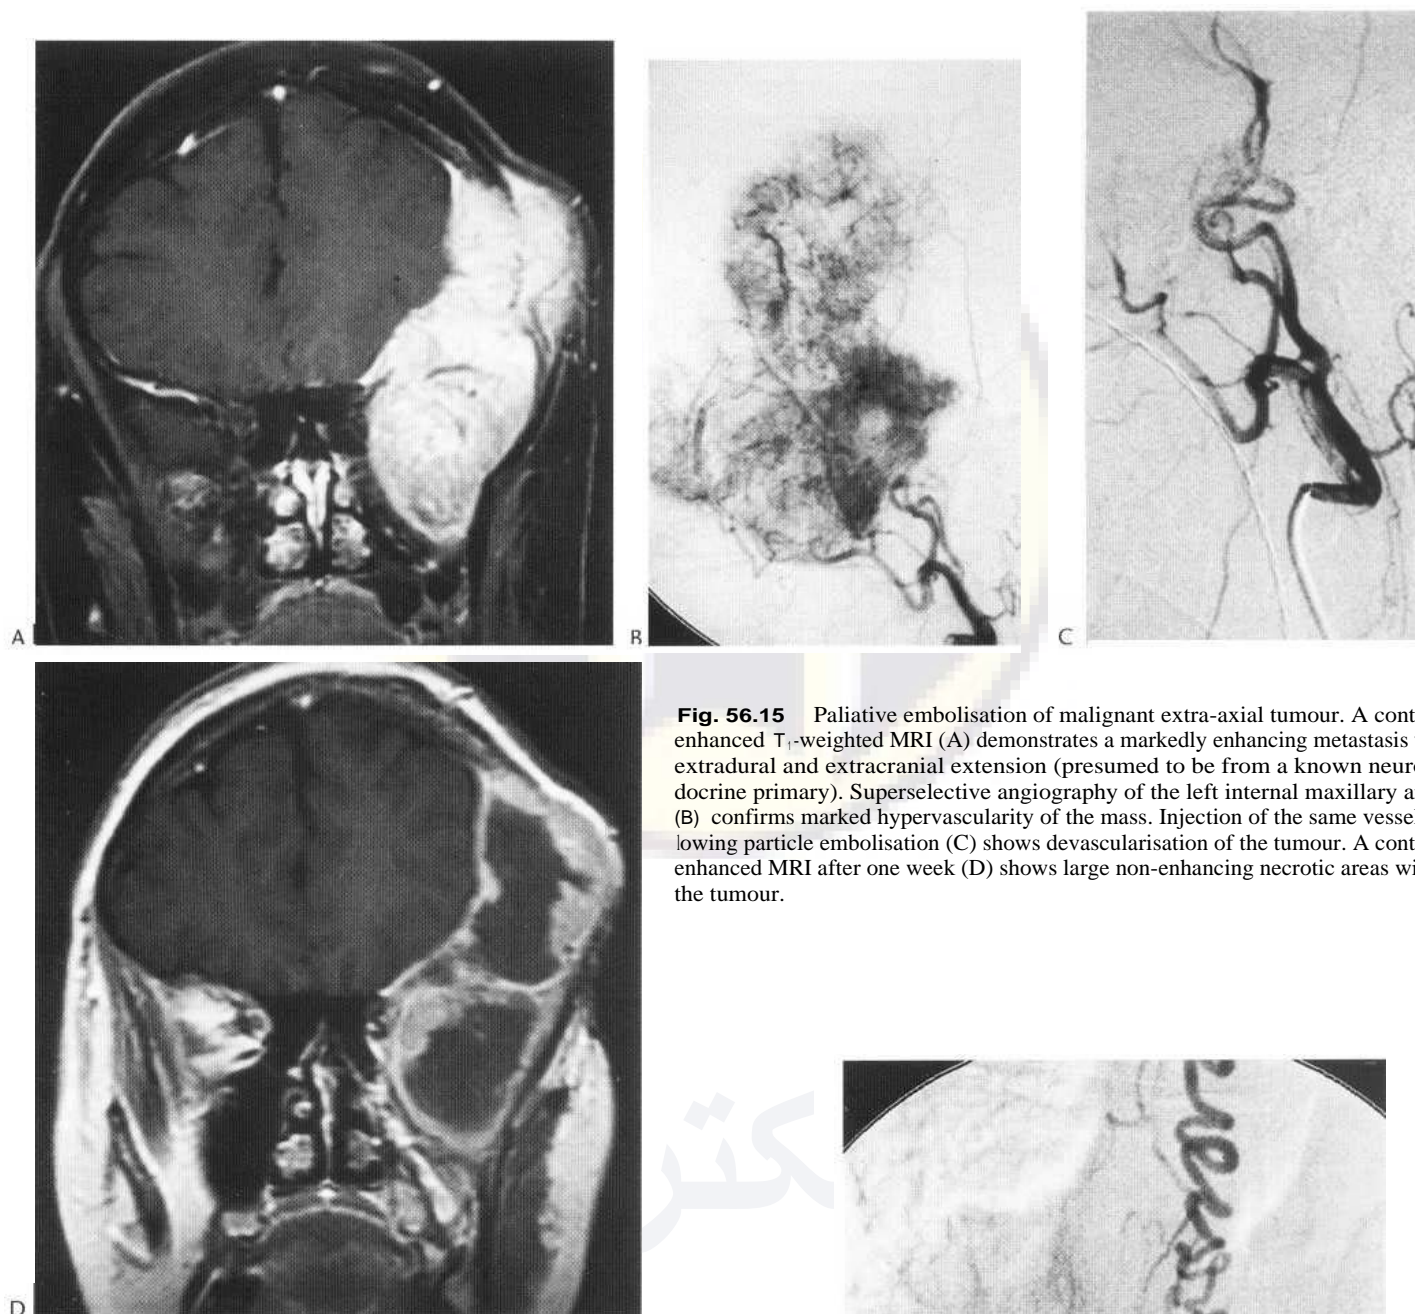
Paliative embolisation of malignant extra-axial tumour. A contrast-enhanced T₁-weighted MRI (A) demonstrates a markedly enhancing metastasis with extradural and extracranial extension (presumed to be from a known neuroendocrine primary). Superselective angiography of the left internal maxillary artery (B) confirms marked hypervascularity of the mass. Injection of the same vessel following particle embolisation (C) shows devascularisation of the tumour. A contrast-enhanced MRI after one week (D) shows large non-enhancing necrotic areas within the tumour.
